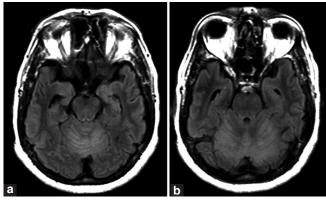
(a,b) FLAIR magnetic resonance imaging showing bilateral symmetrical cerebellar and vermian hyperintensities
